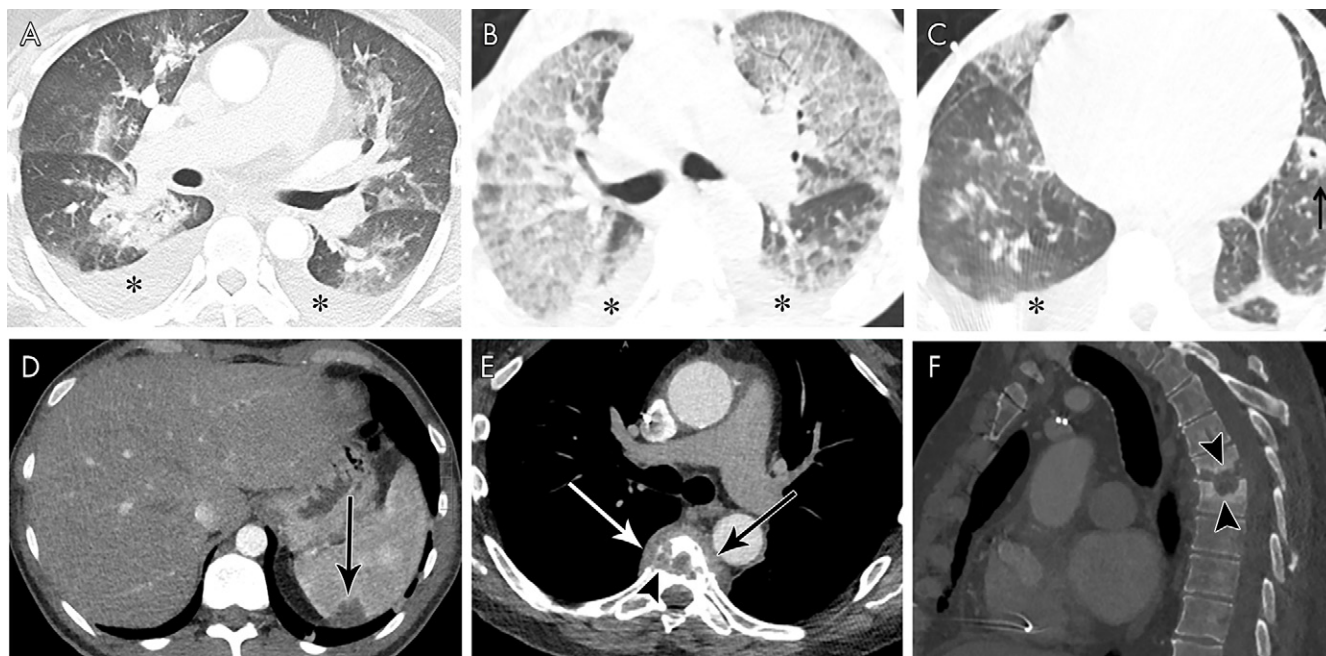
A, Axial contrast-enhanced CT image in a 46-year-old man with mitral and aortic valve infective endocarditis (IE) shows pleural effusions (*) and peribronchial ground-glass and consolidative opacities, suggesting pulmonary edema. B, C, Axial non-contrast-enhanced CT images in a 55-year-old man with multivalvular IE show pleural effusions (*) and upper-zone predominant ground-glass opacities with septal thickening, suggesting pulmonary edema. Left lower lobe cavitating nodule (arrow) represents a septic embolus. D, Axial contrast-enhanced CT image in a 38-year-old man with aortic valve IE shows a splenic peripheral low-attenuation area of infarct (arrow). E, F, Axial (soft-tissue window, E) and sagittal (bone window, F) contrast-enhanced CT images in a 66-year-old man with bioprosthetic aortic valve IE show midthoracic vertebral end-plate destruction and sclerosis (arrowheads) with paravertebral heterogeneous attenuation (arrows) consistent with spondylodiscitis.
